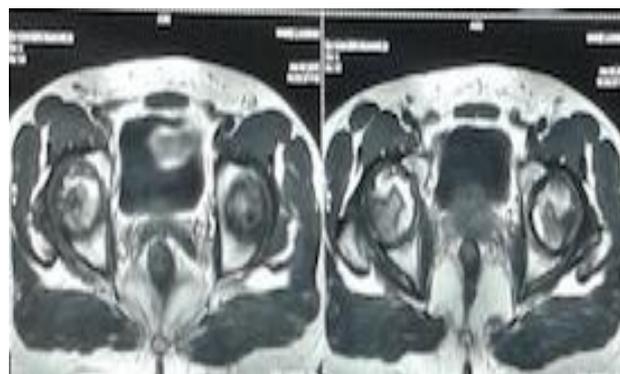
Axial MRI of Pelvis with Both Hip
